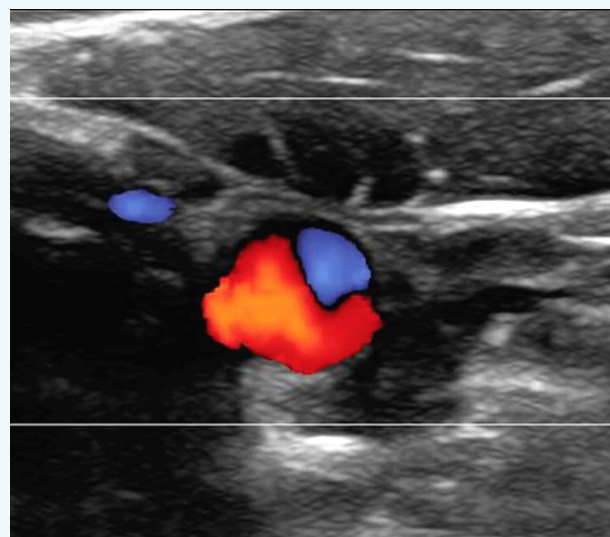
Transverse section through the common carotid artery using color Doppler imaging demonstrates hallmark bi-directional flow in the area of dissection.
